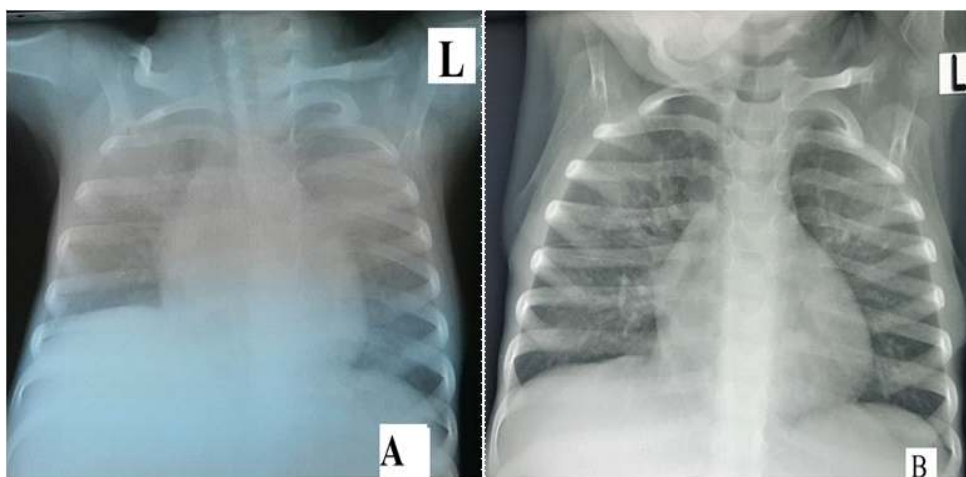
(A) Chest Radiograph showing widespread nodular opacities with patchy shadows in both lung fields worse at the perihilar region and (B) repeated chest radiograph after 2 weeks showing nodular opacities in the perihilar and basal regions.
